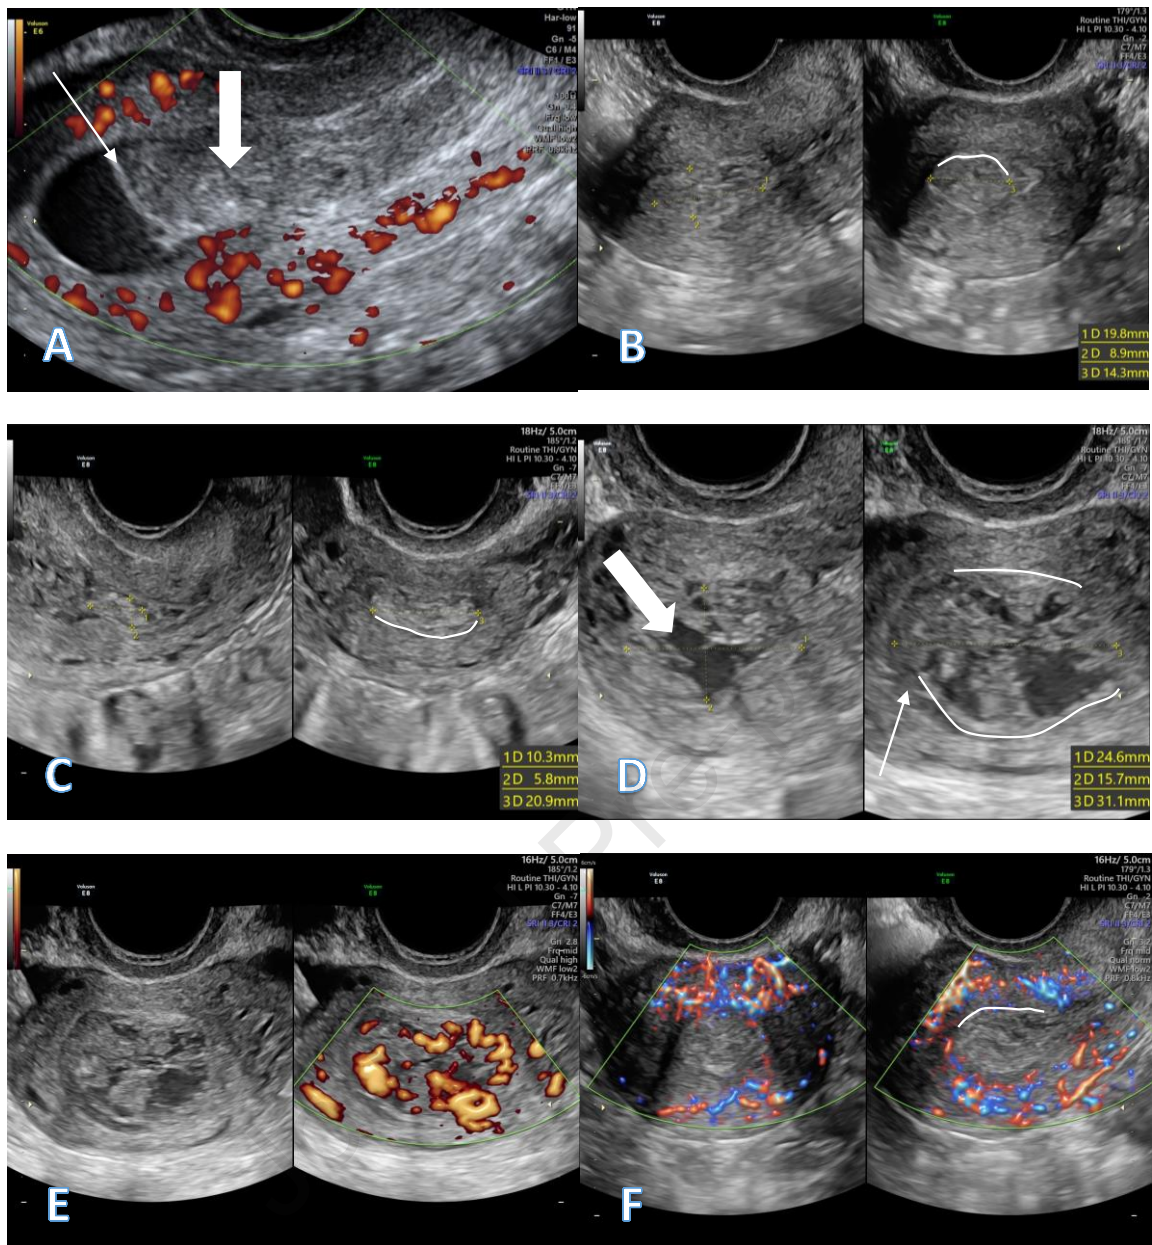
A- mixed echogenic fluid within the endometrial cavity, with a fluid level (thin arrow). Blood clot is below the fluid level (thick arrow). B- RPOC within the endometrial cavity between callipers, White line indicates the part conforming to the endometrial cavity shape, uninterrupted. C- small hyperechoic area of RPOC between callipers. D and E- large amount of RPOC with significant vascularity on power Doppler. White line indicates ha part conforming to the cavity shape, thick arrow indicates a very large blood vessel in keeping with enhanced endo-myometrial vascularity. F- colour Doppler image of RPOC with minimal vascularity. All images indicate the heterogenic appearance of the RPOC with various levels of vascularity within. The common feature is the clear division plane between the tissue and the endo- myometrial layer (white lines). RPOC- retained products of conception.
